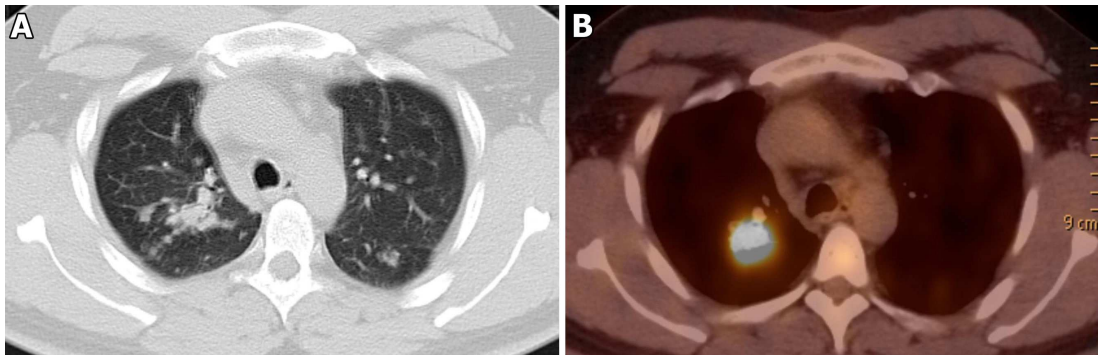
A: CT image of the lungs affected by sarcoidosis [175]. B: fused image, with PET data being overlaid onto the CT image. The area of high metabolic activity is clearly visible. ©Hellerhoff / Wikimedia Commons / used under the terms of the CC-BY-SA 3.0 license.
